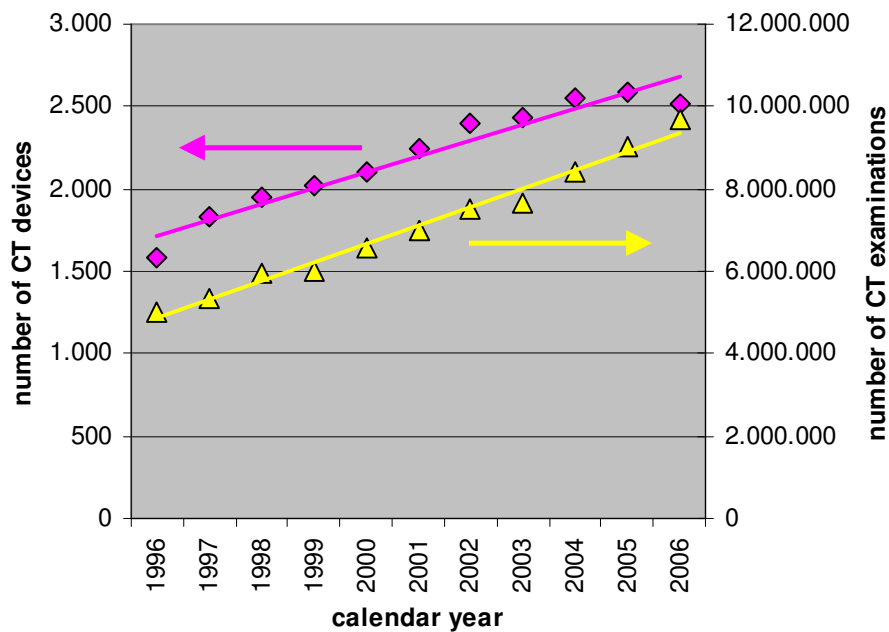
Frequency of CT devices (left ordinate) and of CT examinations (right ordinate) in Germany from 1996 to 2006.
